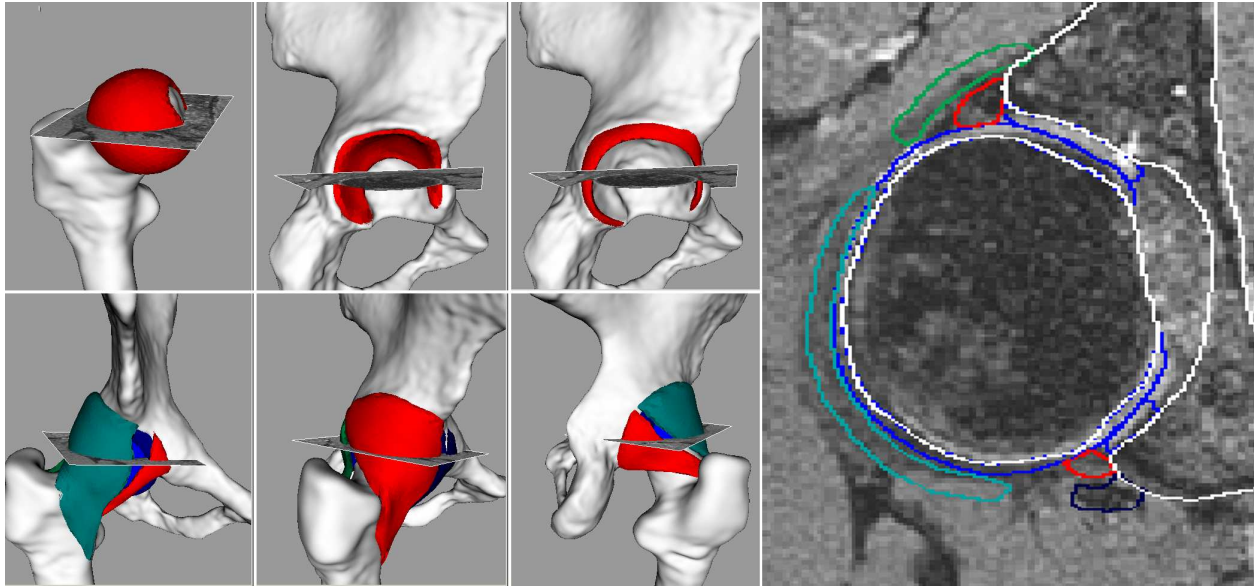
Automatically segmented periarticular tissues using our geometric method. Left (in red): femoral cartilage, acetabular cartilage, labrum, pubofemoral ligament, iliofemoral ligaments, ischiofemoral ligament; Right: MRI cutplane with overlaid models.
